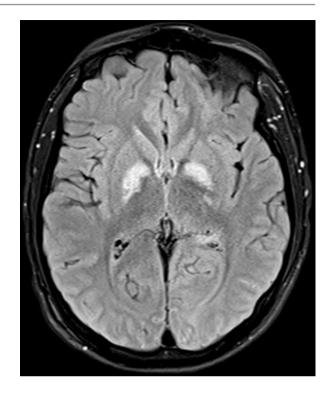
MRI fluidattenuated inversion recovery (FLAIR) sequence demonstrates hyperintensities in the globus pallidus bilaterally
